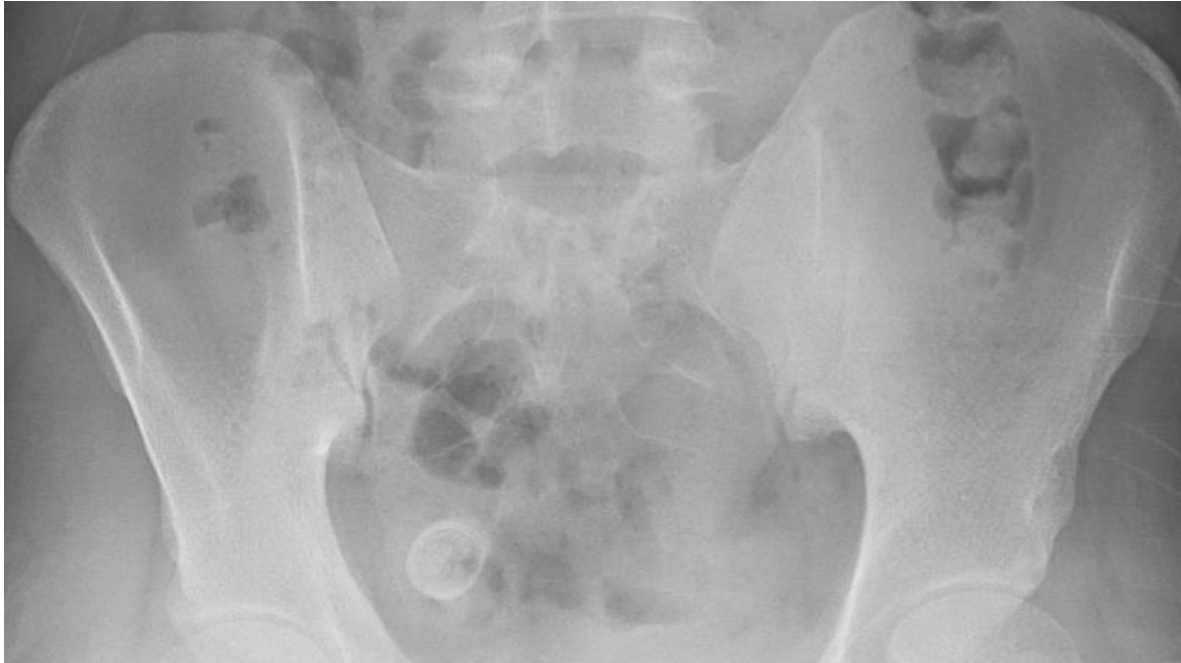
Pelvic X-ray shows an opaque shadow at the pelvis.
